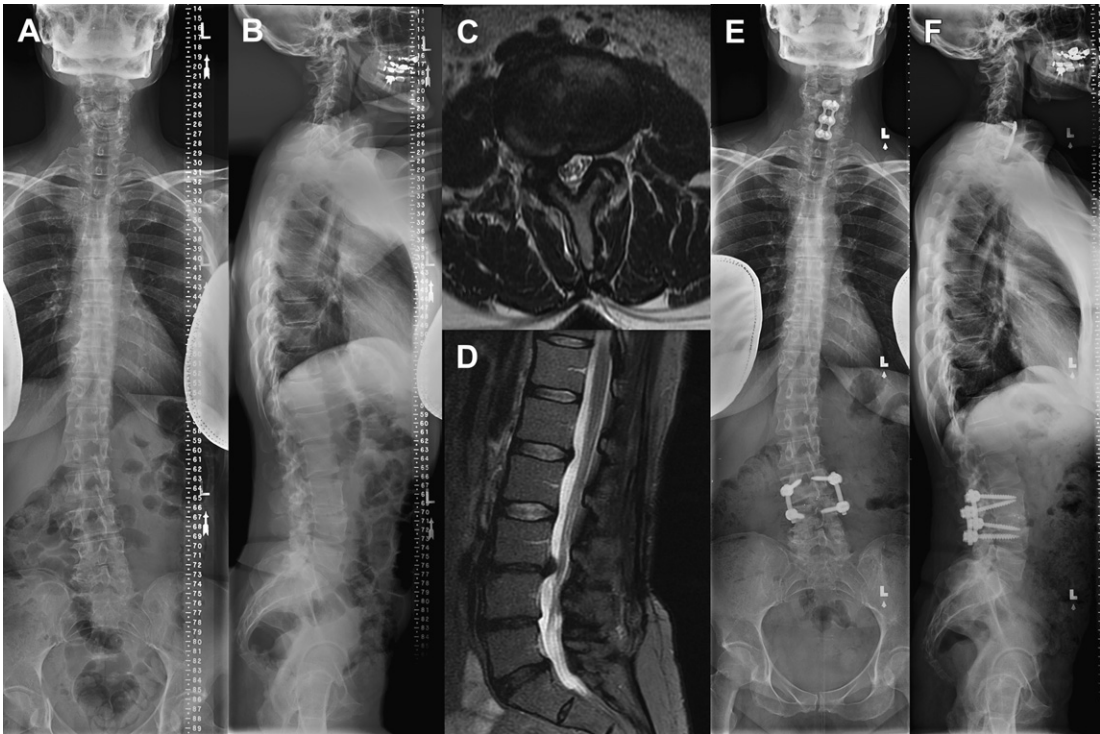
A 52-year-old woman with radicular right leg pain and back pain. (A, B) 91.44-cm (36-in) preoperative radiographs showed a mild lumbar scoliosis (Cobb angle of 16°) and maintained sagittal balance (SVA = 2.0 cm). (C, D) T2-weighted axial and sagittal MRI shows a right herniated disk causing lateral recess stenosis at the L3 to 4 level. (E, F) Postoperative 91.44-cm (36-in) radiographs after a minimally invasive L3 to 4 TLIF (MiSLAT II treatment).
